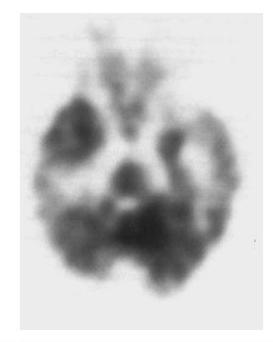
EEG on day 3, after FDG-positron emission tomography (PET) scan (right) showed left-sided temporal-periodic lateralized epileptiform discharges (PLEDs). PLEDs were also evident on days 1 and 2 and on day 3 before the PET scan. The FDG-PET scan image was generated to display the contrast between left temporal lobe and other brain structures. Left mesiotemporal lobe showed markedly increased FDG uptake, compatible with seizure activity. Background cerebral FDG uptake was not altered except in the areas previously damaged by infarct, where uptake was reduced.
